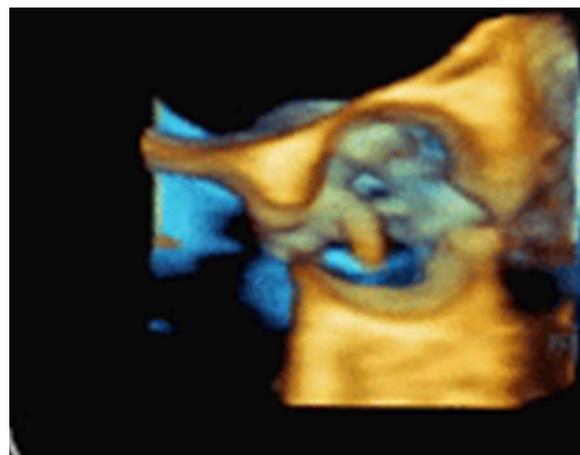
3D Trans-oesophageal echocardiography during trans-catheter aortic valve implantation: positioning of the guidewire across the aortic valve.
